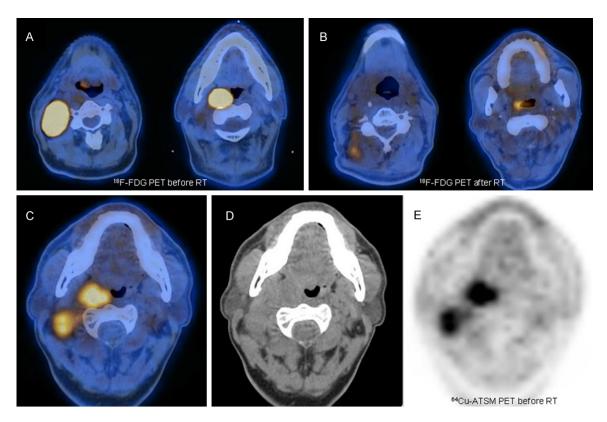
Example of a patient with localized head and neck squamous cell carcinoma (HNSCC) who was investigated with <sup>18</sup>F-FDG PET before (A) and after the end of RT (B). At staging the patient had undergone <sup>64</sup>Cu-ATSM PET/CT (C-E) documenting some mild uptake at the level of the primary tumor in the left tonsil (SUV<sub>max</sub> 1.85). As is visible in (B) the patient achieved a complete response after treatment.
